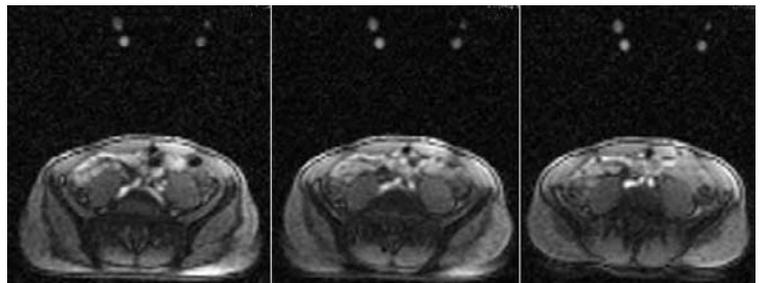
Volunteer experiment showing the motion of the robot head. After the new coordinates were transferred to the MRI system the slice position was updated and the passive markers became visible.
